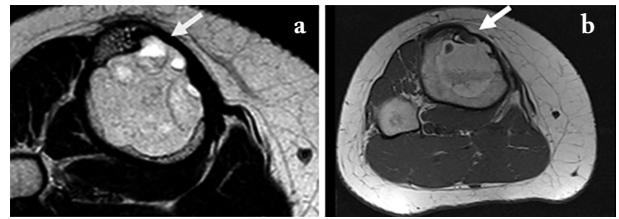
(Axial view) Cystic lesion lesion with high intensity signal in T2-weighted sequence (a) and low intensity signal in T1-weighted sequence (b)
